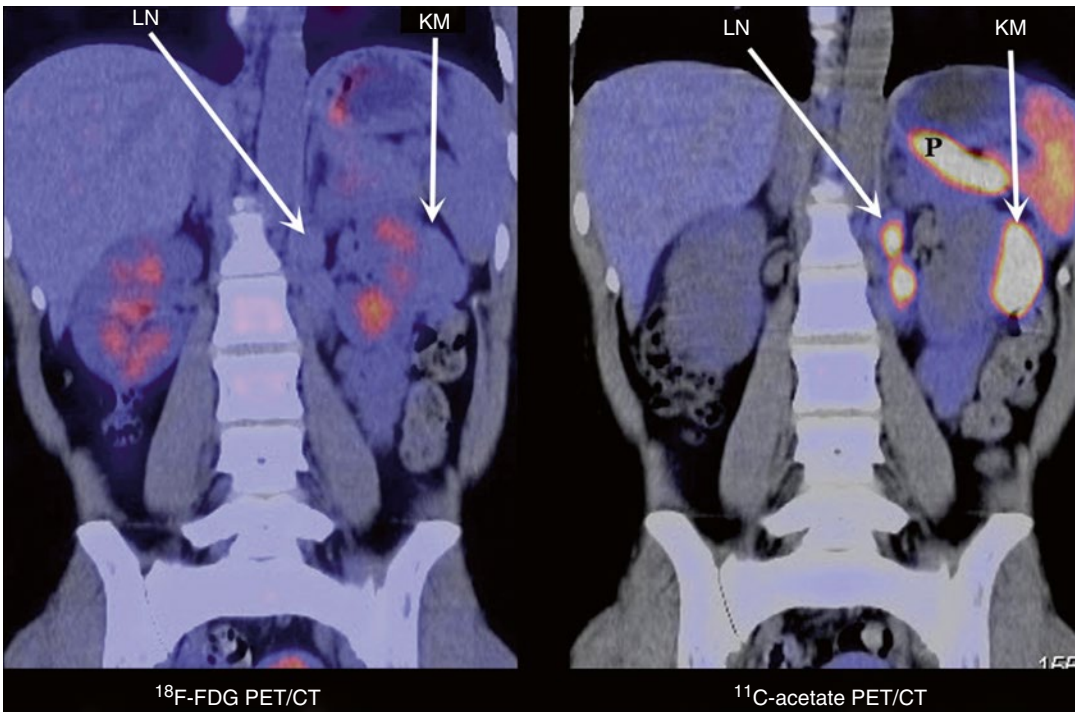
^{11}C -acetate and ^{18}F -FDG PET/CT of multicentric fat-poor angiomyolipoma with lymph node involvement. *KM* kidney mass, *LN* a chain of para-aortic nodes, *P* pancreas
